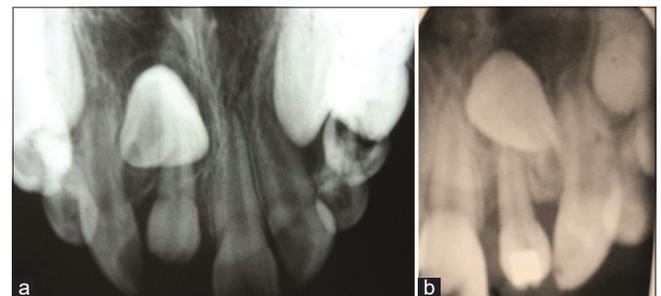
(a) Intraoral occlusal radiograph showing unerupted rootless maxillary left central incisor and supernumerary lying adjacent to it; (b) radiograph showing the supernumerary being brought down by orthodontic traction
